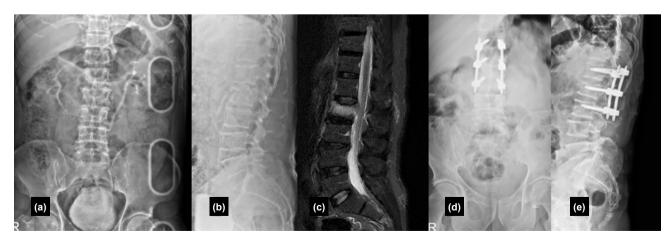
(a) Anteroposterior X-ray of a patient diagnosed with an AO Type A3 fracture of the L2 vertebra, taken in the emergency room after trauma. (b) Lateral X-ray of a patient diagnosed with an AO Type A3 fracture of the L2 vertebra, taken in the emergency room after trauma. (c) Sagittal T2 Short Tau Inversion Recovery (STIR) magnetic resonance image showing the L2 fracture. (d) Anteroposterior X-ray after percutaneous posterior instrumentation surgery. (e) Lateral X-ray after percutaneous posterior instrumentation surgery.
